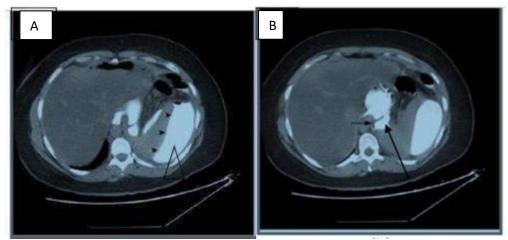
Staple line in the upper leaking. (A) Upper abdominal fluid collection seen on axial CT scan (arrow heads). (B)Upper abdominal axial CT showing rich contrast material at the incision site (black arrow) (10).
